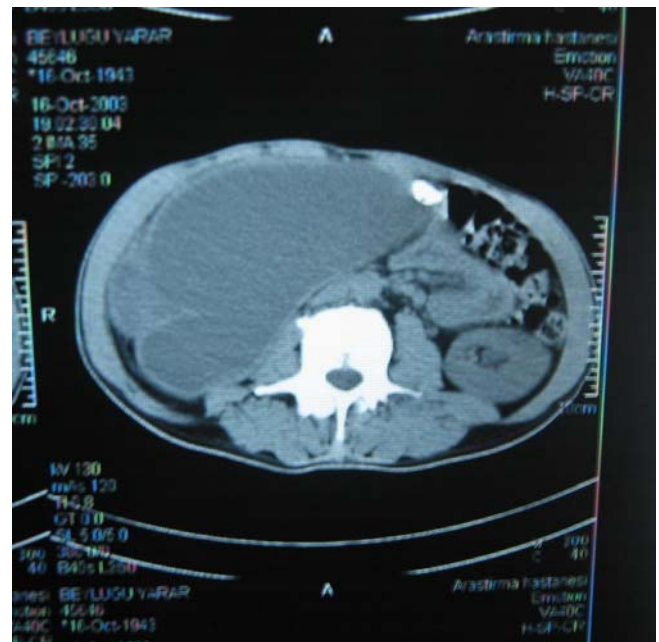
Unenhanced abdominal CT demonstrated the hydronephrosis in the right kidney. Note that the pelvic stone is located on the left
